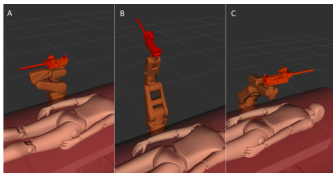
Static configurations of the Abu system. Pose A is the storage configuration assumed by the robot when not in use. Pose B is assumed to elevate the camera to localize the Ultrasound probe. Pose C is for loading and removing the biopsy tool.
